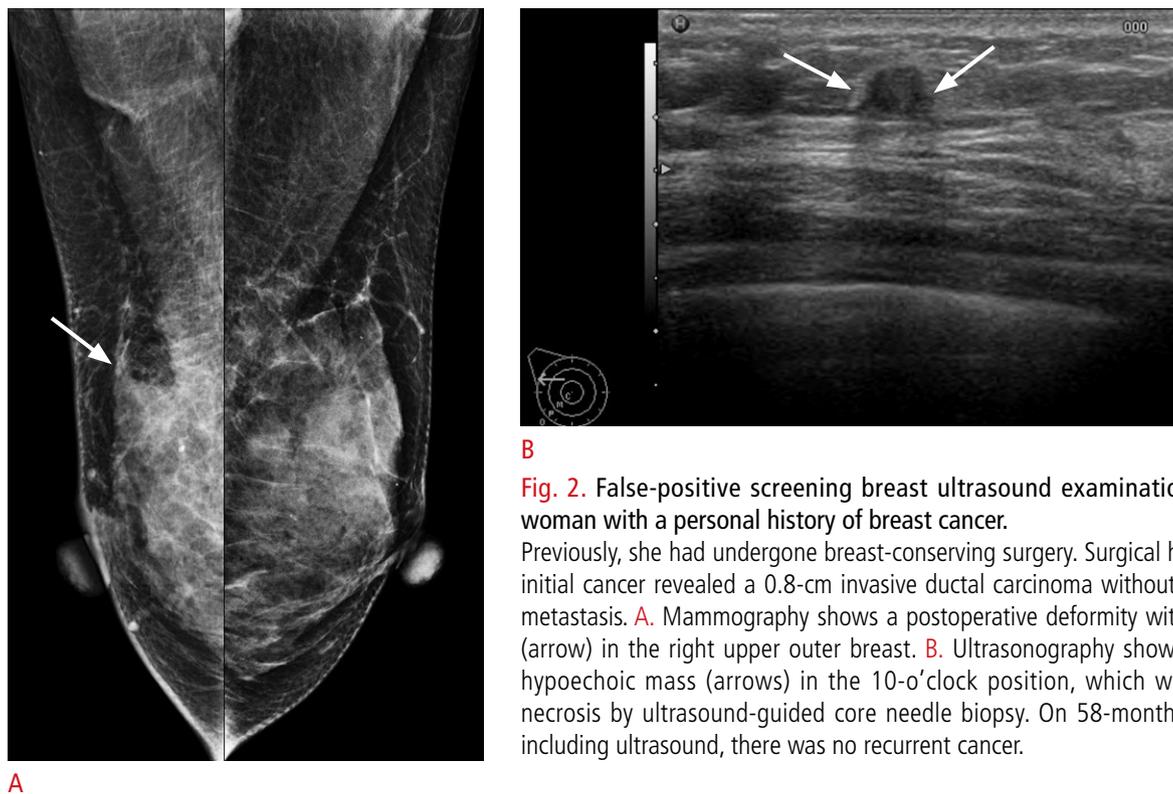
False-positive screening breast ultrasound examination in a 38-year-old woman with a personal history of breast cancer.
